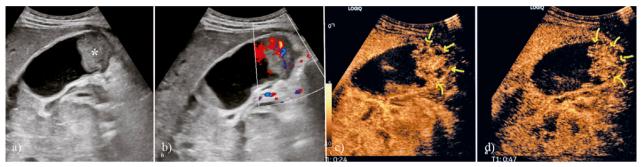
Neuroendocrine gallbladder carcinoma: a) grayscale (asterisk); b) colour Doppler (colour signal observed at the tumor periphery); c) and d) CEUS exploration (arrows).
